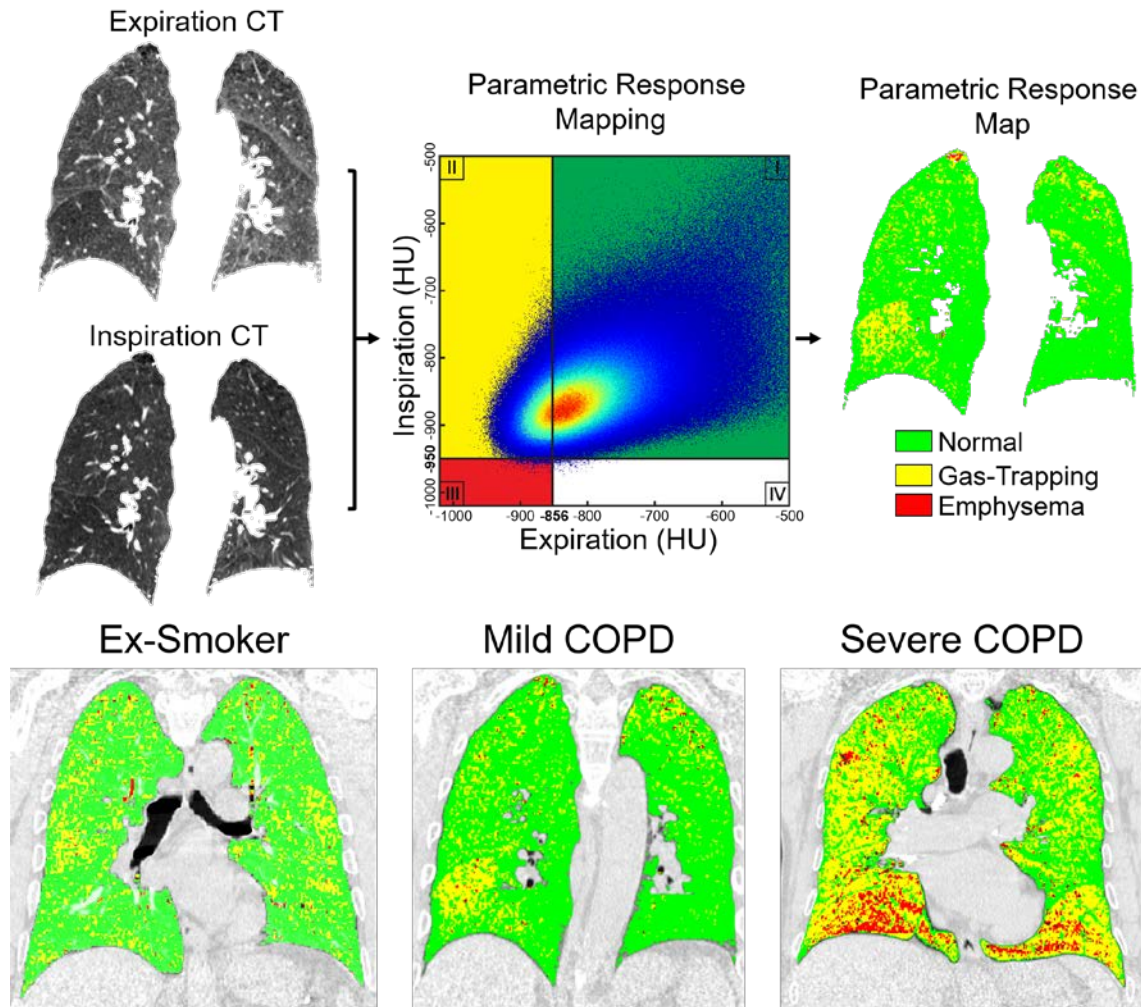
Parametric Response Mapping of Co-registered Inspiratory-Expiratory CT Images
